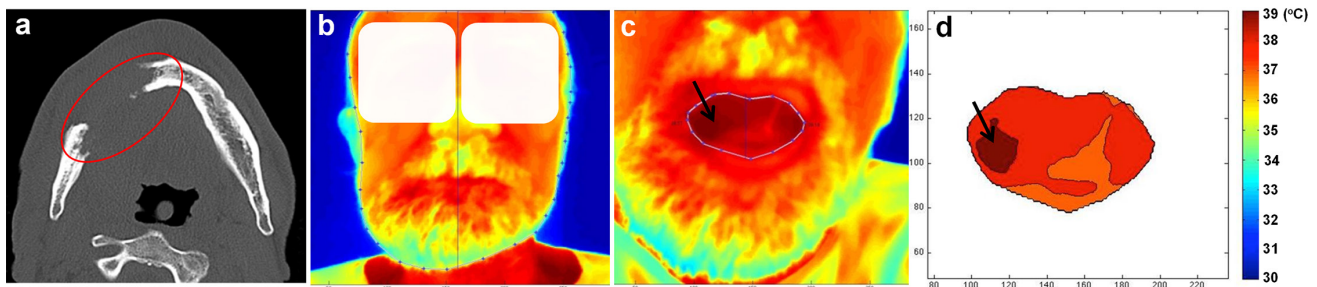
CT vs IRT images obtained in a 64-year-old male patient with obvious pathological changes of malignant soft tissue tumour (SCC) on the right side: in axial CT image of affected jaw (a) vs TIs in frontal closed-mouth (b) and in open-mouth projections (c). Note: in the CT image (a) of affected jaw there is a wide bone destruction zone of the body of the mandible on the right (marked by oval). In the TI of the mouth cavity, before and after segmentation (c, d, respectively), there is asymmetrical temperature on the right side, which the lesion region highlighted in dark (marked by arrow). Other notations are same as in Figure 2. IRT, infrared thermography; TI, thermal image; SCC, squamous cell carcinoma.
